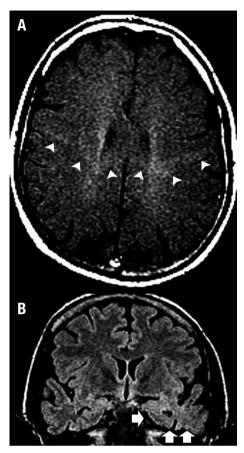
A man of 42 years of age presented with UMN + LMN signs associated with dementia and language-speech abnormalities (his mother had died at 67 years old with a diagnosis of ALS-FTD). [A] Axial T1 MTC image showed an abnormally selective hyperintensity throughout the corticospinal tracts, predominantly on the left side, assuming a typical 'W-like appearance' crossing the corpus callosum (arrowheads). [B] Coronal FLAIR image depicted a marked atrophy in the left temporal pole with blurring of the grey/white matter differentiation (arrows). Note the abnormal hyperintensity in the left amygdala and hippocampus.
